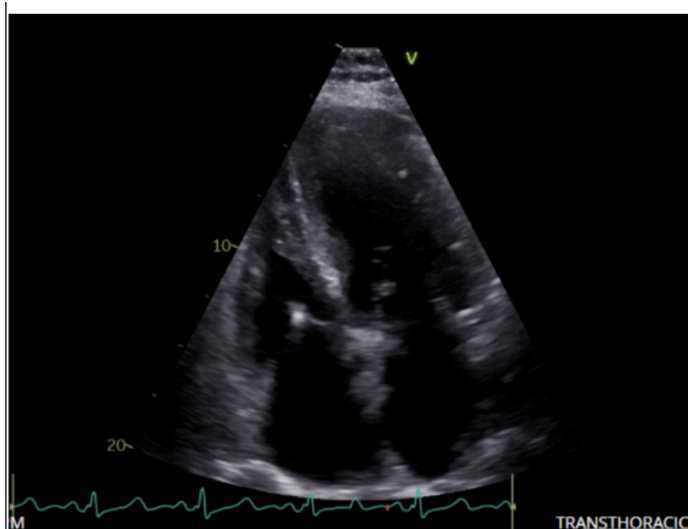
Transthoracic apical four chamber view demonstrating biventricular hypertrophy.
